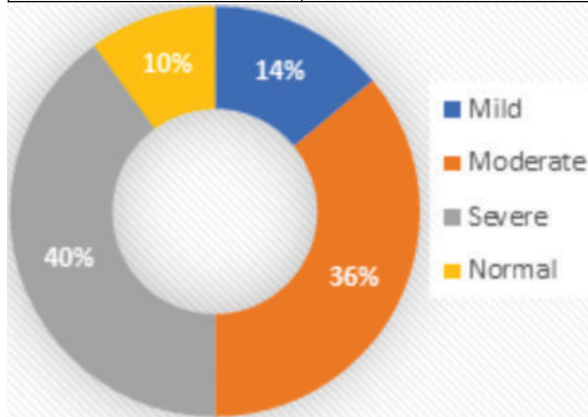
CT Severity score
